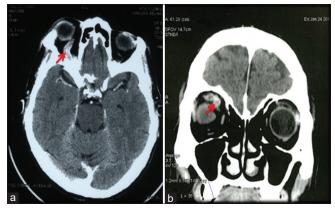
Computed Tomography Scan of the orbits: (a) axial section, (b) coronal reconstruction of the venous phase of computed tomography angiography: The arrow is pointing to dilated right superior ophthalmic vein thrombosis and enlarged extraocular muscles
